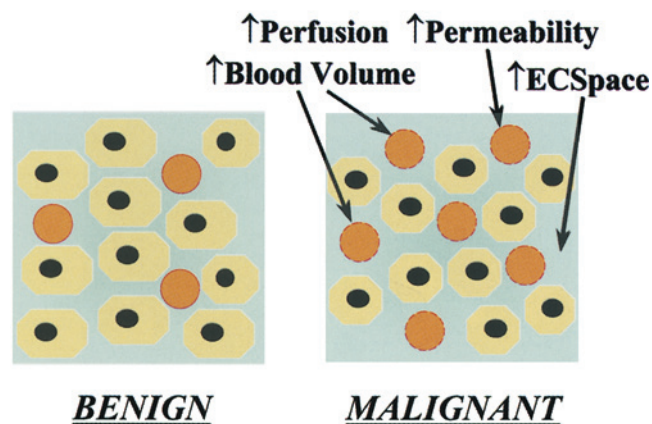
Neovascularisation of tumour–tissue results in increased numbers of vessels with incomplete basement membranes. These pathological features translate to increased blood volume, perfusion, permeability and extracellular space measurements on functional CT
